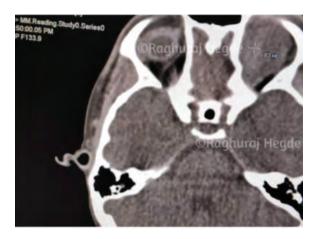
CT scan with the lesion showing the Hounsfield units (HU) value of +63.
